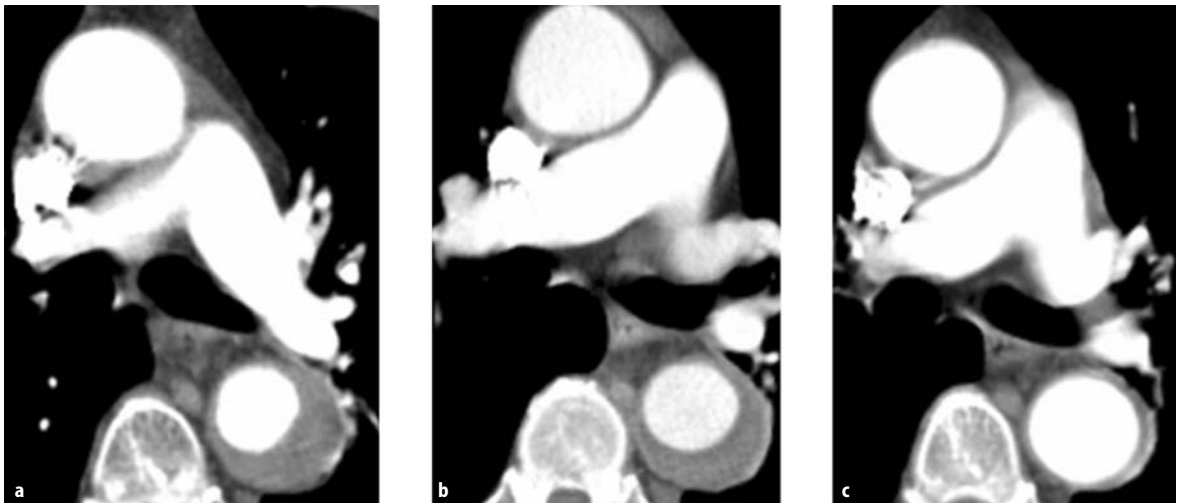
CT evolute sequence of a distal IAH. At admission (a), on the ninth day in hospital (b) and 2 months after admission (c)
